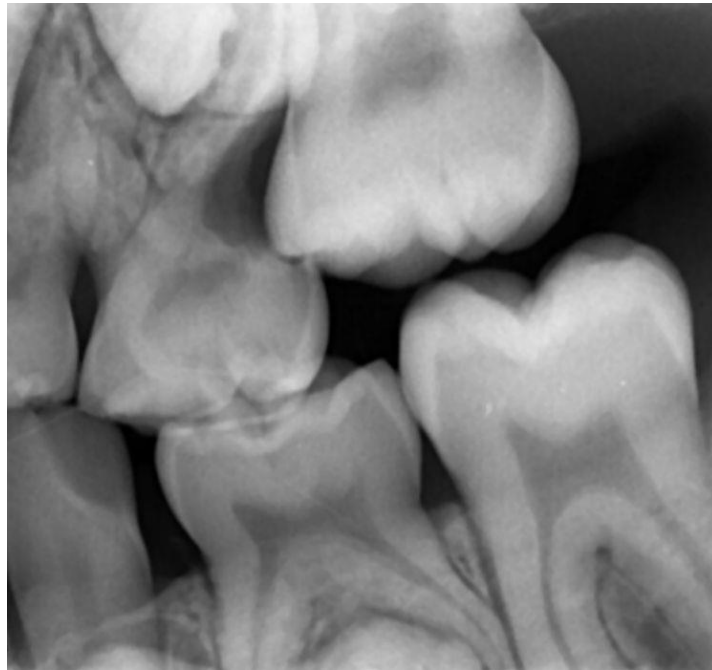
A bitewing radiograph showing extensive resorption on the distal aspect of the second deciduous molar. Open communication between the mouth and dental pulp can lead to symptoms including pain.
